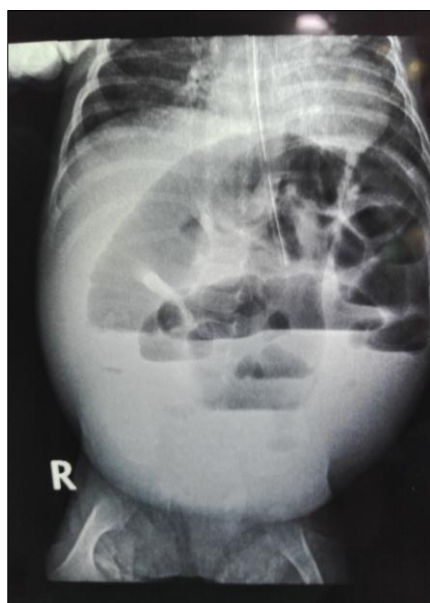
An erect radiograph in a new-born with HD demonstrating dilated bowel and absent pelvic gas.
